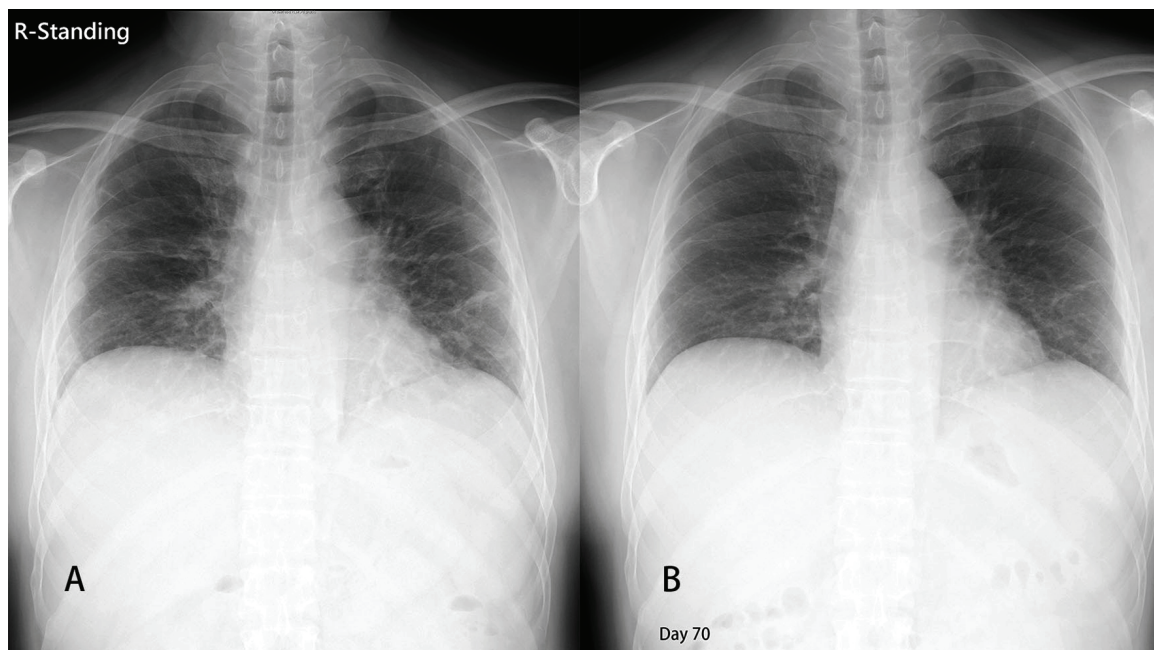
A-B: Follow-up chest radiography on day 40 and day 70.
